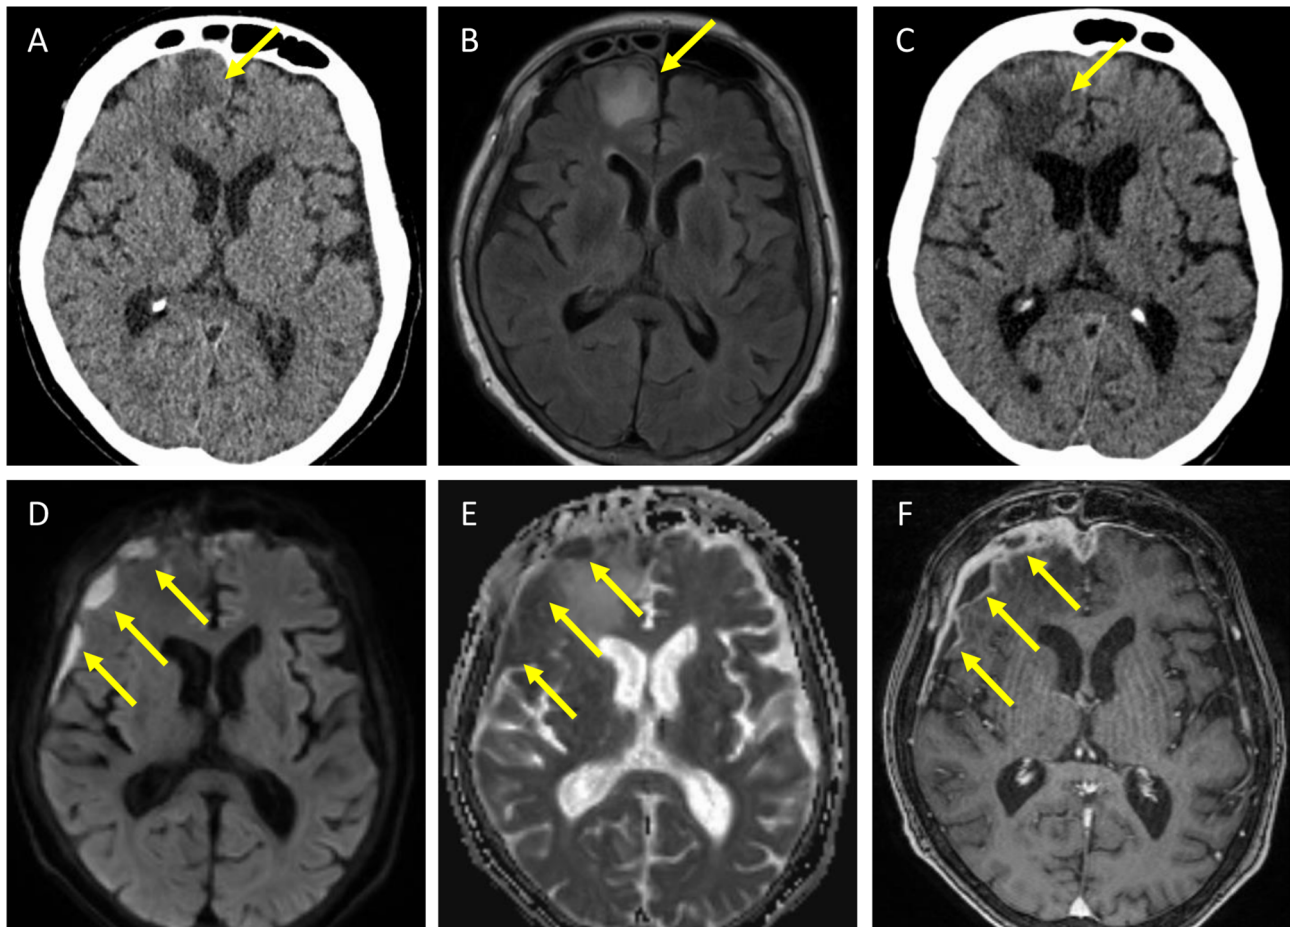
Imaging of the head before and at the time of the diagnosis of intracranial subdural empyema. A) Head computed tomography (CT) image showing a low-density area in the right frontal lobe (arrow). B) Fluid-attenuated inversion recovery-magnetic resonance imaging (FLAIR MRI) showing a high-signal intensity area in the right frontal lobe (arrow). C) Head CT image showing an enlarged low-density area in the right frontal lobe (arrow). D) Diffusion-weighted MRI showing high-signal fluid collection on the cerebral surface of the right frontal lobe (arrows). E) Apparent diffusion coefficient (ADC) map showing low-signal fluid collection on the cerebral surface of the right frontal lobe (arrows). F) Contrast-enhanced MRI showing capsular formation with a contrast effect (arrows).
